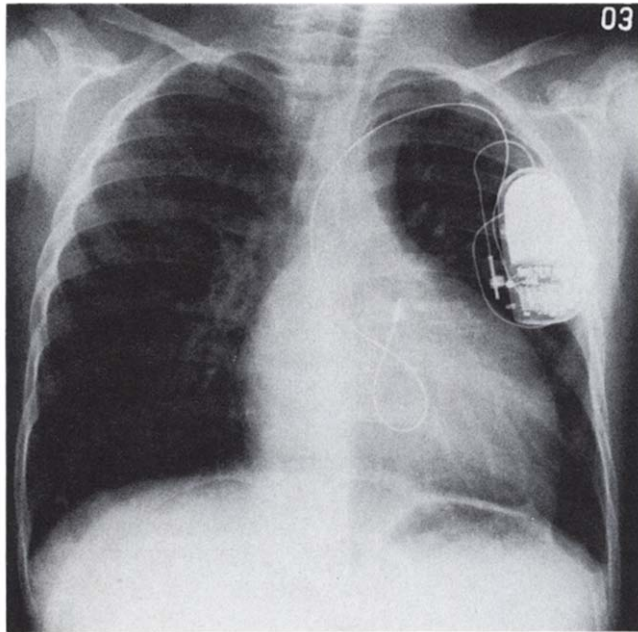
Chest radiograph showing the use of an endocardial screw-in lead with an atrial demand pacemaker in a 9 year old child after Mustard's operation. The lead is screwed into the roof of the anatomic left atrium and a loop is left in the atrium to try to accommodate growth.
